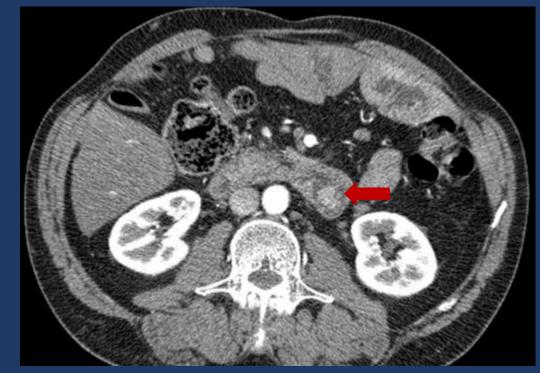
Contrast-enhanced CT shows an adenoma (arrow) in duodenum.
